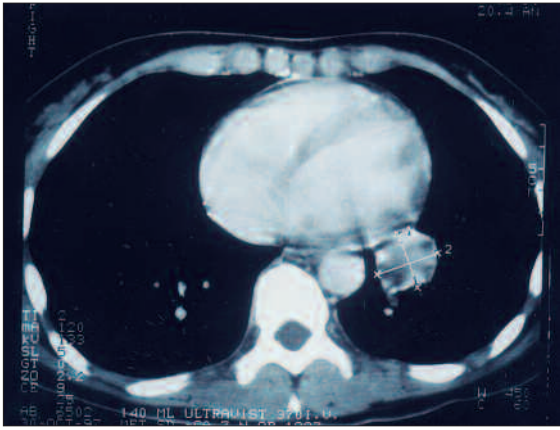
CT image of a 44-year-old female patient with a 6-cm metastasis in the left lower lobe, contiguous to the pericardium.
